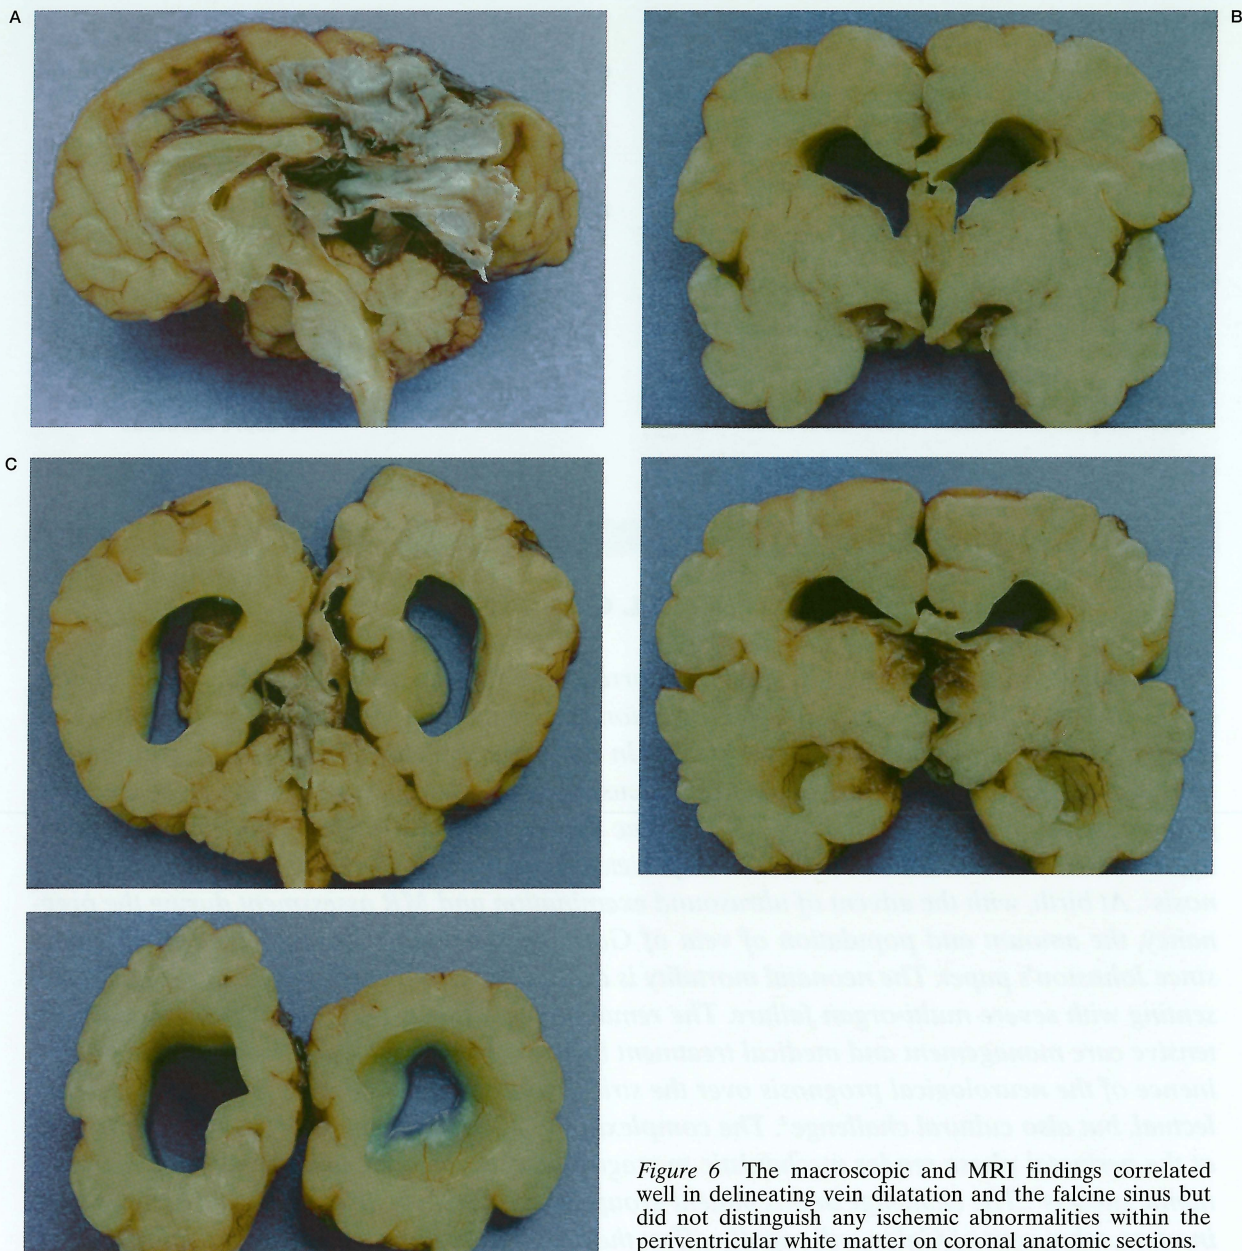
The macroscopic and MRI findings correlated well in delineating vein dilatation and the falcine sinus but did not distinguish any ischemic abnormalities within the periventricular white matter on coronal anatomic sections.
